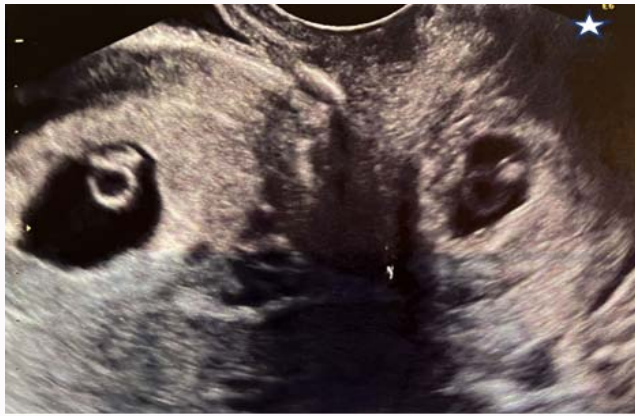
Transvaginal ultrasound image performed at 6 weeks demonstrating a viable cervical (star) along with an intrauterine gestation.
